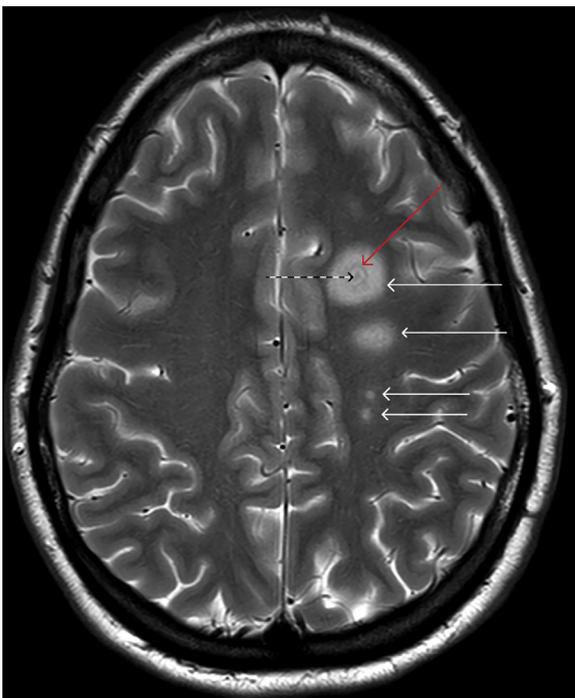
Magnetic resonance imaging with gadolinium enhancement revealing multiple left-sided septic emboli with associated vasogenic edema (white arrows). The largest lesion (dashed arrow) has surrounding cerebritis (red arrow).
